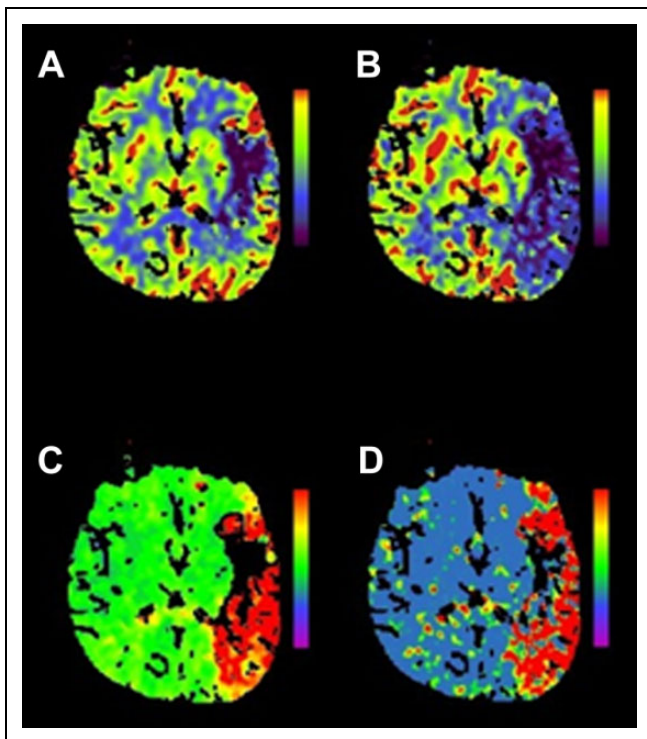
Multimodal CT mismatch (or “penumbra”). Panel (A) is a cerebral blood volume (CBV) map. The dark area noted in the left frontal operculum suggests low contrast volume in the region and is considered a surrogate for infarcted tissue, or the “infarct core.” The other maps—cerebral blood flow (CBF) in panel (B), time to peak (TTP) in panel (C), and mean transit time (MTT) in panel (D)—are different measures of contrast movement through cerebral vasculature (see Table 3) and clearly involve much more of the left hemisphere than the CBV map. This discordance is referred to as a multimodal CT mismatch or “penumbra” and may represent tissue at risk of infarction but potentially salvageable by reperfusion therapy. Siemens SOMATOM, syngo perfusion software. CT indicates computed tomography.
